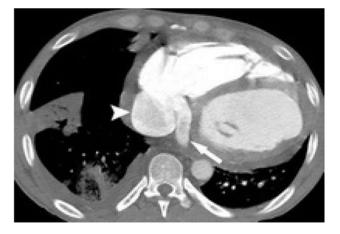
Contrast-enhanced axial CT scan showing significantly enlarged right and left ventricles and a dilated inferior vena cava (arrowhead) and coronary sinus (arrow), as well as pericardial fluid, right-sided pleural effusion, and parenchymal consolidation in the lower lobe of the right lung
